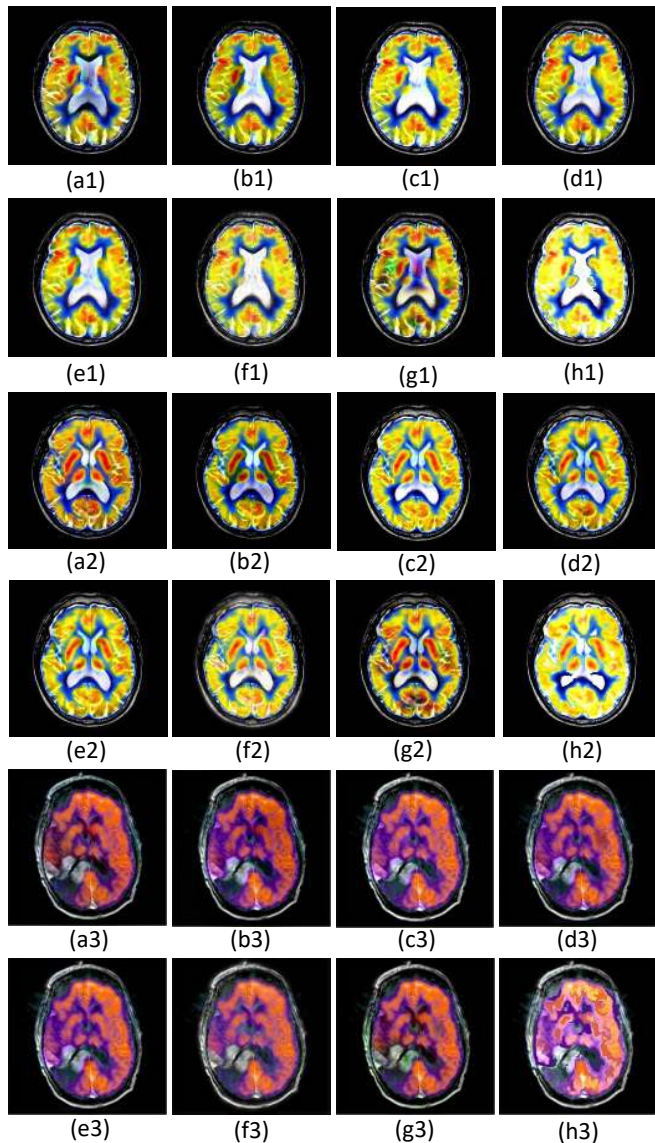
Results of three pairs of MRI-PET images fused by eight different image fusion methods. Fused images (a1),(a2),(a3) are LP-SR based method; (b1), (b2), (b3) CNN based method; (c1), (c2), (c3) CFL based method; (d1), (d2), (d3) NSST-PAPCNN based method; (e1), (e2), (e3)NSCT-PC-LLE based method; (f1), (f2), (f3) LRD based method; (g1), (g2), (g3) NSCT-SR based method; (h1), (h2), (h3) the proposed method.
